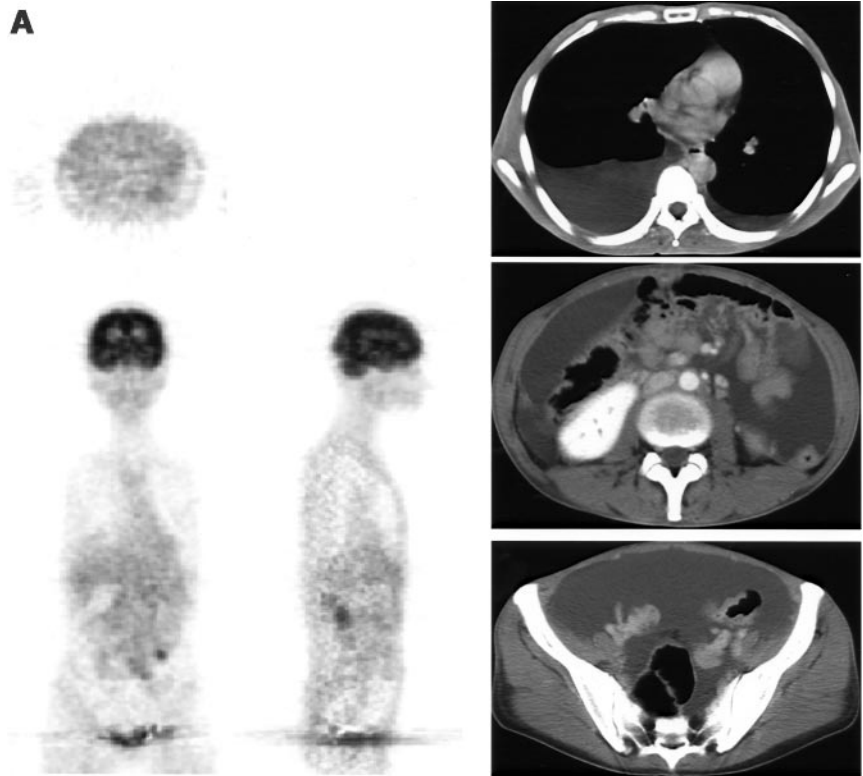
Cases with peritonitis or pleuritis carcinomatosa. (A) Recurrence to peritoneal and thoracic cavities after total gastrectomy (patient S09). CT images show large amount of pleural effusion and ascites that were diagnosed as malignancy by cytology, but ^{18}F -FDG PET shows no findings. (B) Borrmann type III lesion with peritonitis carcinomatosa (patient S05). Barium radiographic image shows pyloric stenosis (arrows, a). CT images show large amount of ascites and nodal masses on peritoneal wall (arrows, b). ^{18}F -FDG accumulates in sites corresponding to primary lesion (arrows, c) and nodal masses (arrows, d) on peritoneal wall.
